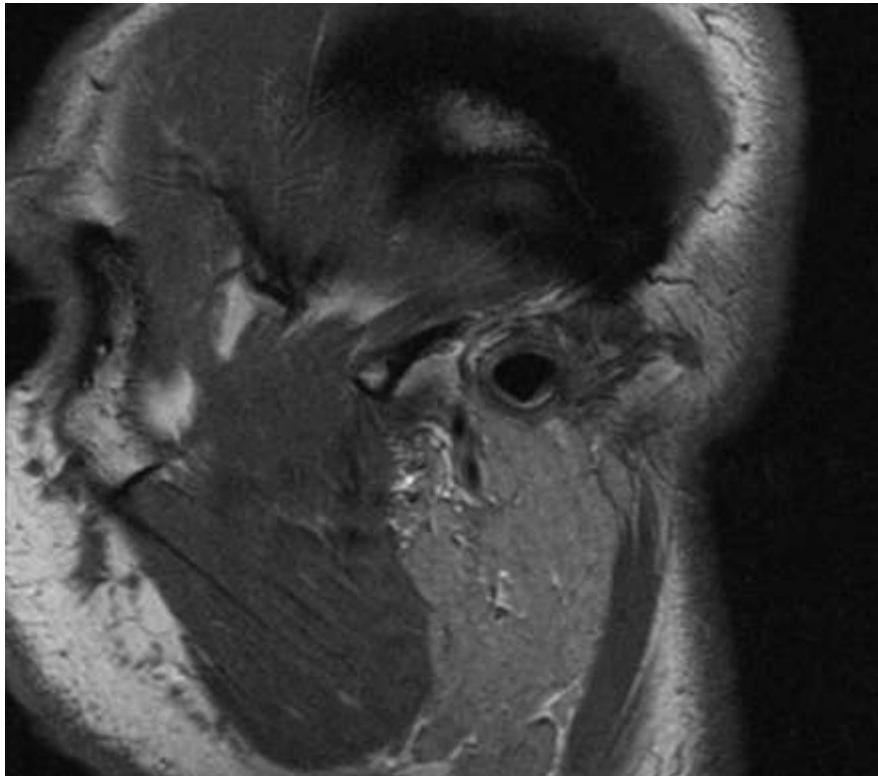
MRI sagittal slice demonstrating normal right parotid gland
